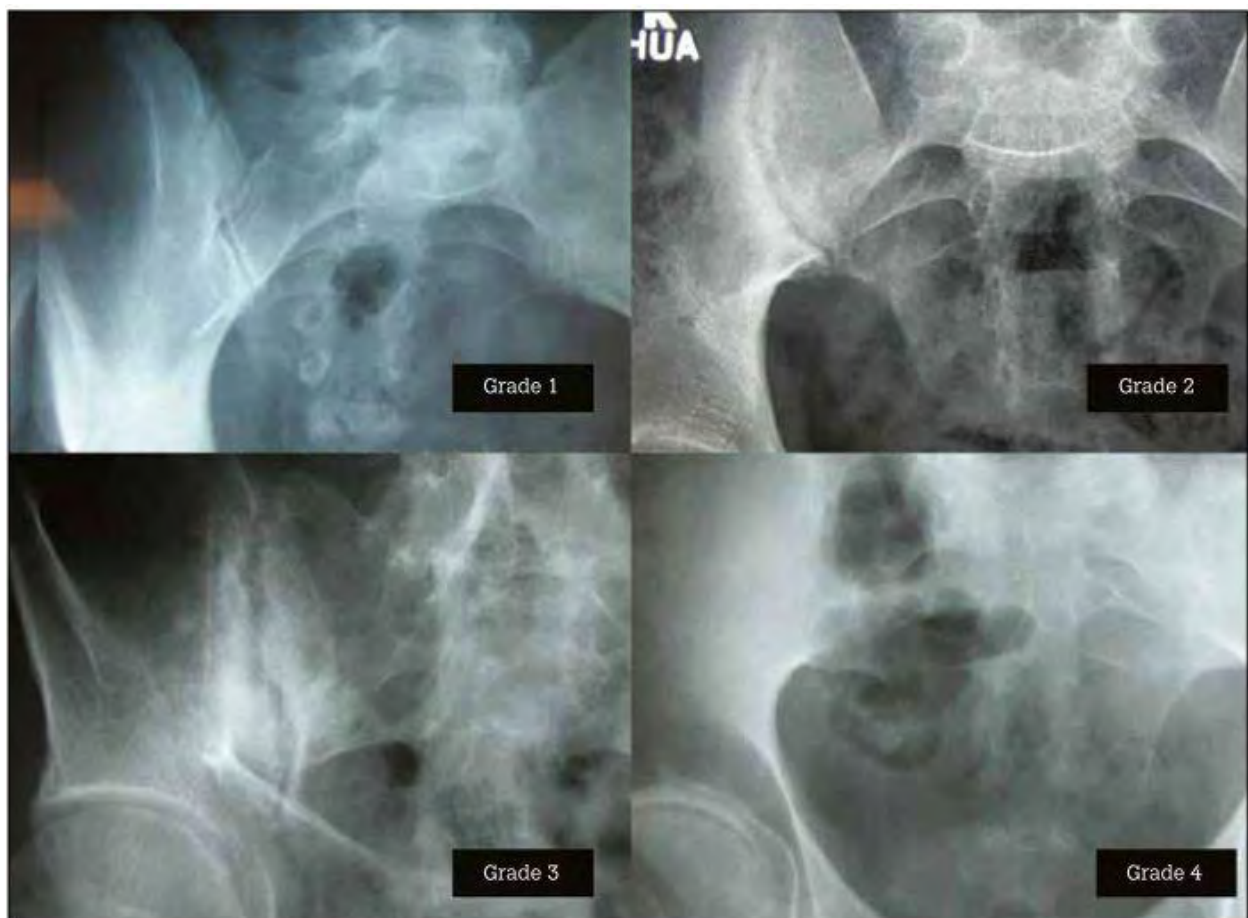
Radiographic grading of sacroiliac joints (Golder & Schachna, 2013)
